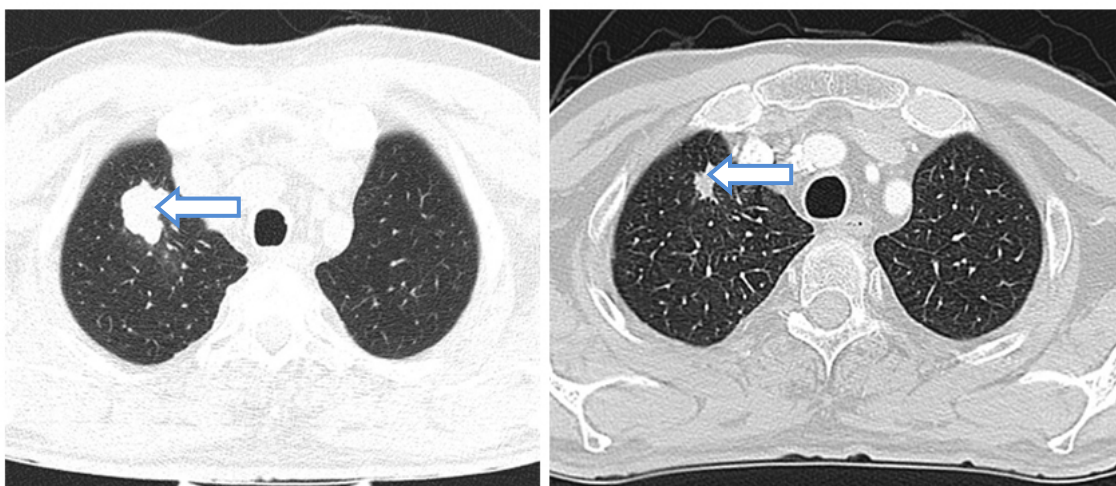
CT Exams Comparing the Pulmonary Mass at Diagnosis (right) and the Pulmonary Mass after Chemoradiation (left).
